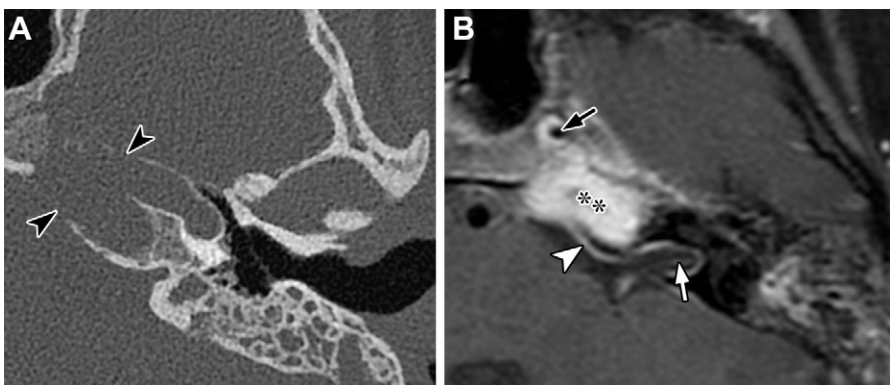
Petrous apicitis and the Gradenigo triad in a 13-year-old adolescent girl who presented with left lateral rectus palsy. (A) Axial temporal bone CT image shows cortical destruction of the petrous apex (arrowheads). (B) Axial contrast-enhanced T1W FS MR image shows extensive enhancing soft tissue and/or phlegmon in the petrous apex (*), vasospasm of the cavernous internal carotid artery (black arrow), meningeal enhancement (meningitis) (arrowhead), and abnormal cranial nerve enhancement in the internal auditory canal (white arrow).
